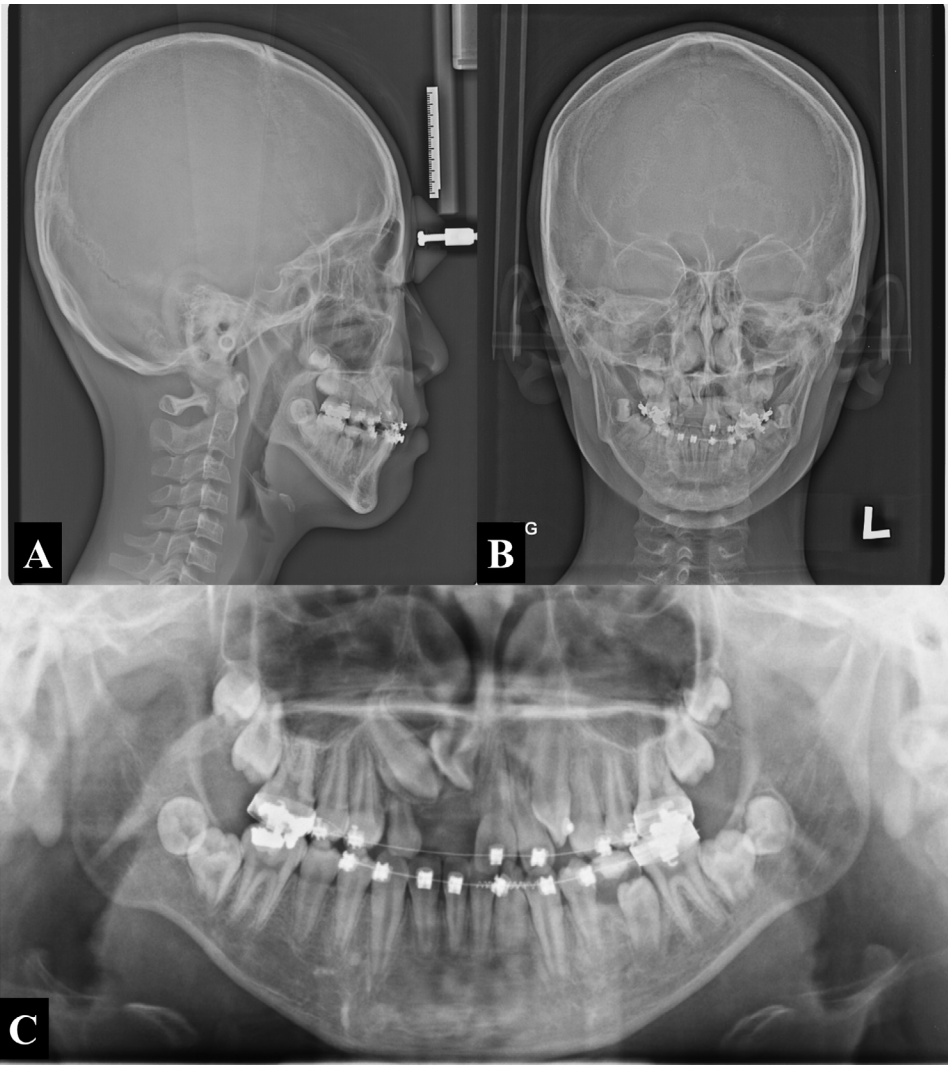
Pretreatment radiographs: (A) lateral cephalogram; (B) postero-anterior cephalogram; and (C) panoramic radiograph.
